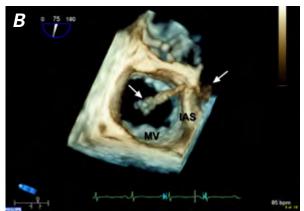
Three-dimensional transesophageal echocardiograms show the intracardiac thrombus-in-transit (arrows) at the levels of A) the interatrial septum and B) the mitral valve.
